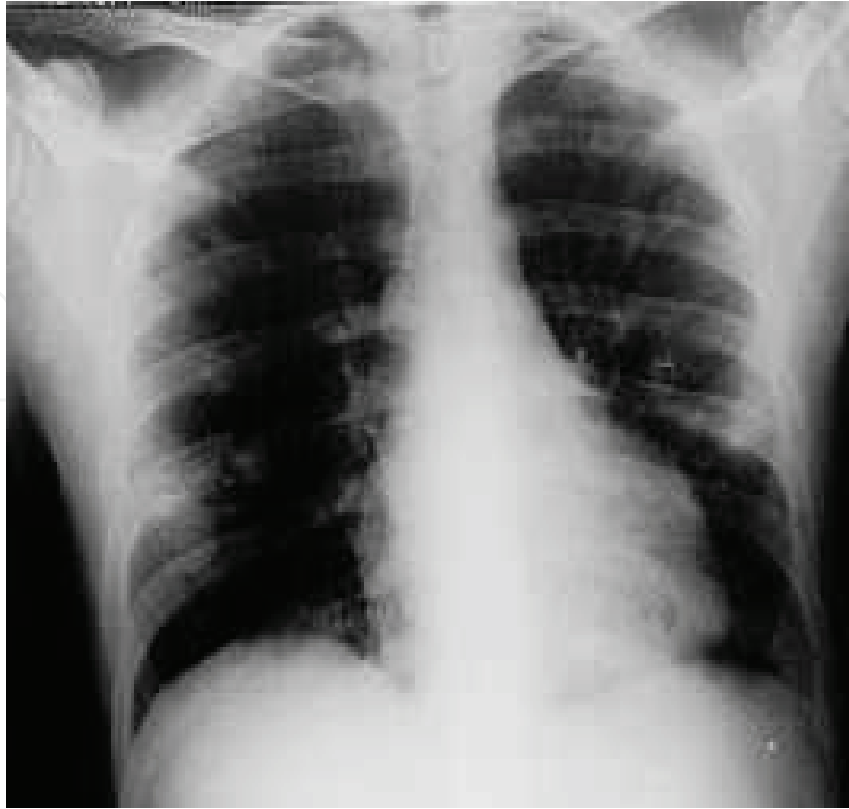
Chest X-ray showing bilateral opacities and nodules, corresponding to septi emboli
